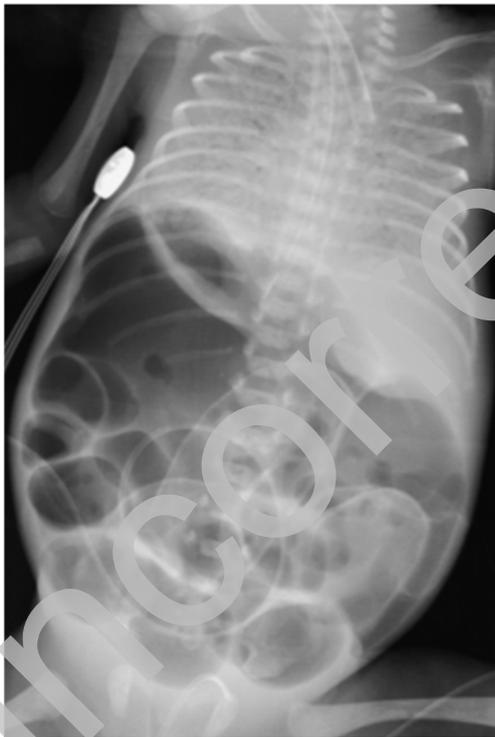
The abdomen X-Ray of the baby with diffuse distention in necrotizing enterocolitis
